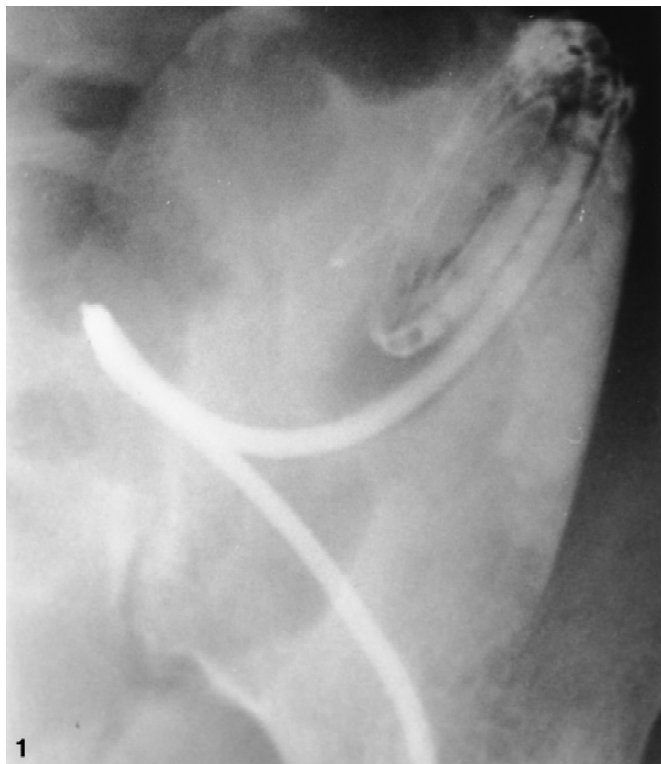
Typical radiographic appearance of omental wrap. Catheter is displaced out of the pelvis. Contrast lines both the lumen and the exterior of the catheter, and intraluminal filling defects, representing ingrowth of omentum, are seen.
